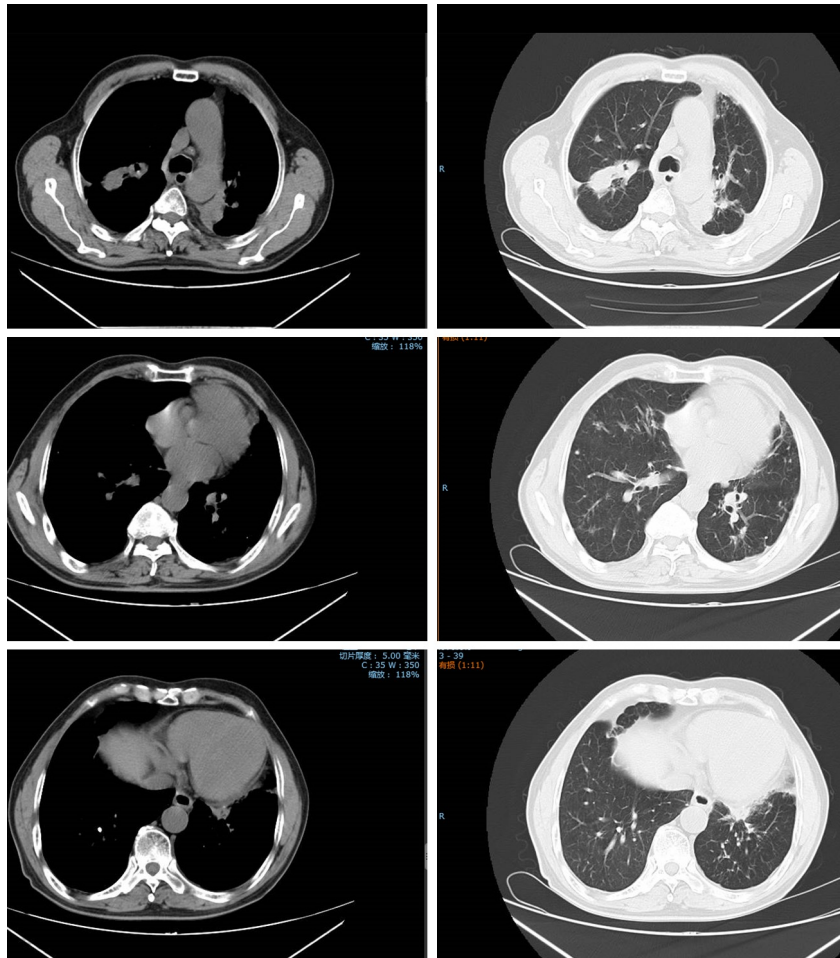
Typical images of upper, middle and lower lung from the patient's chest CT Nine months after treatment.
